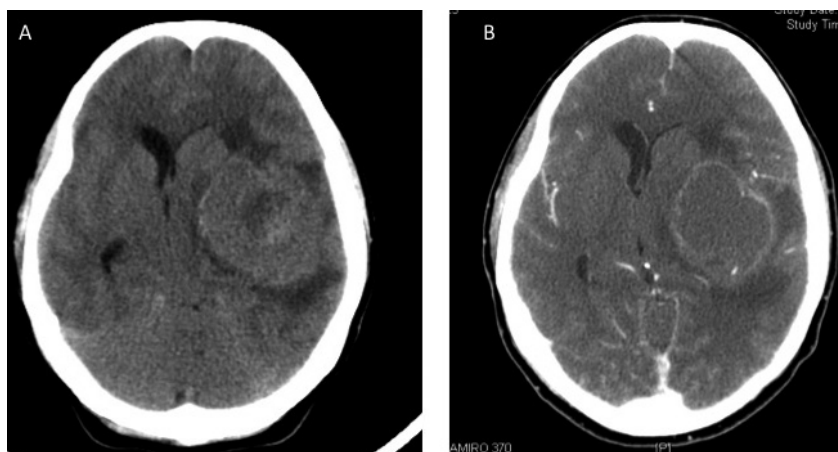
A) Pre-operative CT scan that shows the voluminous tumor in the left temporal lobe. B) After iopamiro injection is evident the ring enhancement of the cystic component.
